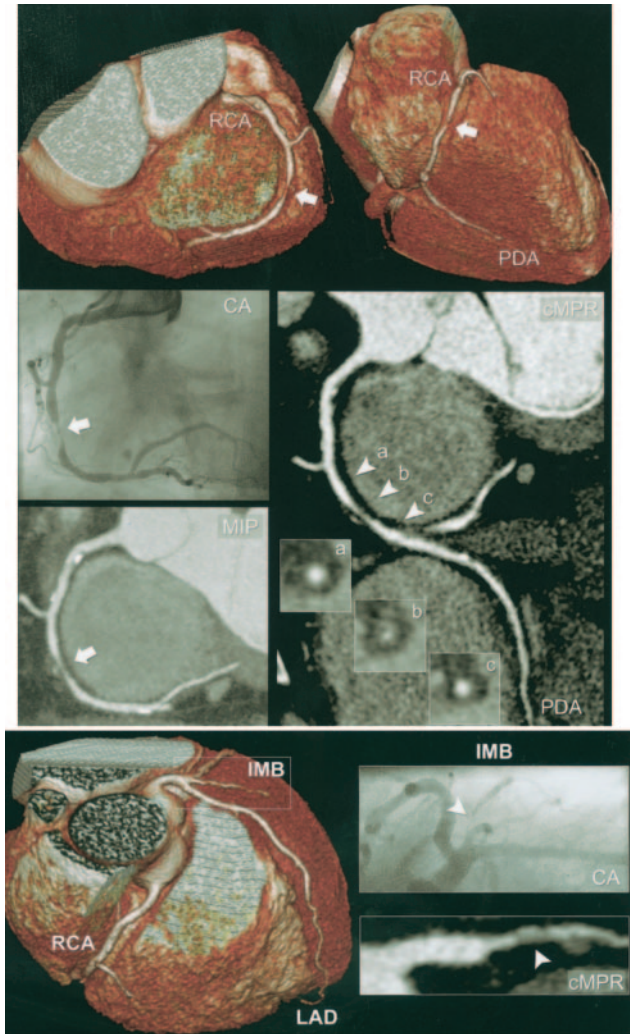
a, CT coronary angiogram and corresponding conventional angiogram of the right coronary artery (RCA) in a patient presenting with stable angina pectoris and a calcium (Agatston) score of 79. The arrow indicates a significant lesion located at the mid RCA. Cross-sectional CT images show a large noncalcific plaque (b) and a normal coronary lumen proximal and distal to the lesion (a, c). Note that the volume-rendered images (colored images) provide an excellent anatomic overview of the coronary arteries but should not be used to score the presence and degree of coronary stenoses. b, Volume-rendered CT image (colored image) providing an overview of the coronary anatomy and showing a small (lumen diameter, 1.5 mm) intermediate branch (IMB). A detailed curved multiplanar reconstructed (cMPR) CT image reveals the presence of a significant stenosis (arrowhead) located at the proximal IMB, which was confirmed on the conventional angiogram (CA). The patient was correctly classified as having 2-vessel disease on the CT scan. MIP indicates maximum-intensity projection; PDA, posterior descending coronary artery; RCA, right coronary artery.
